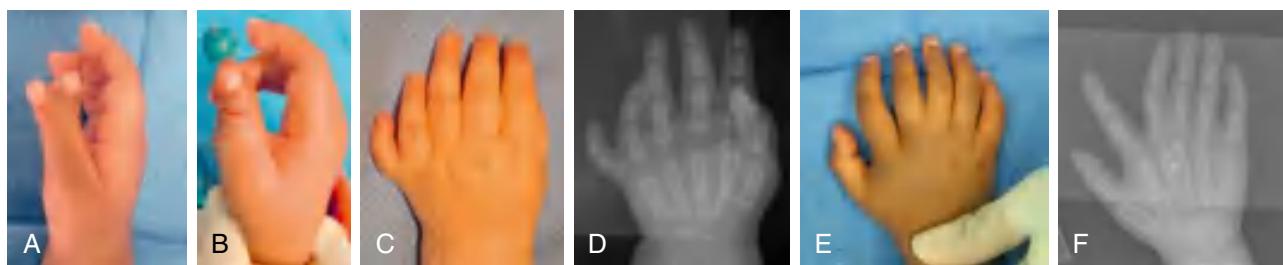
A and B, Preoperative and postoperative pictures of a Wassel II thumb duplication. C, Clinical photograph. D, Radiograph postaxial polydactyly. E, Clinical photograph. F, Radiograph of central polydactyly.
